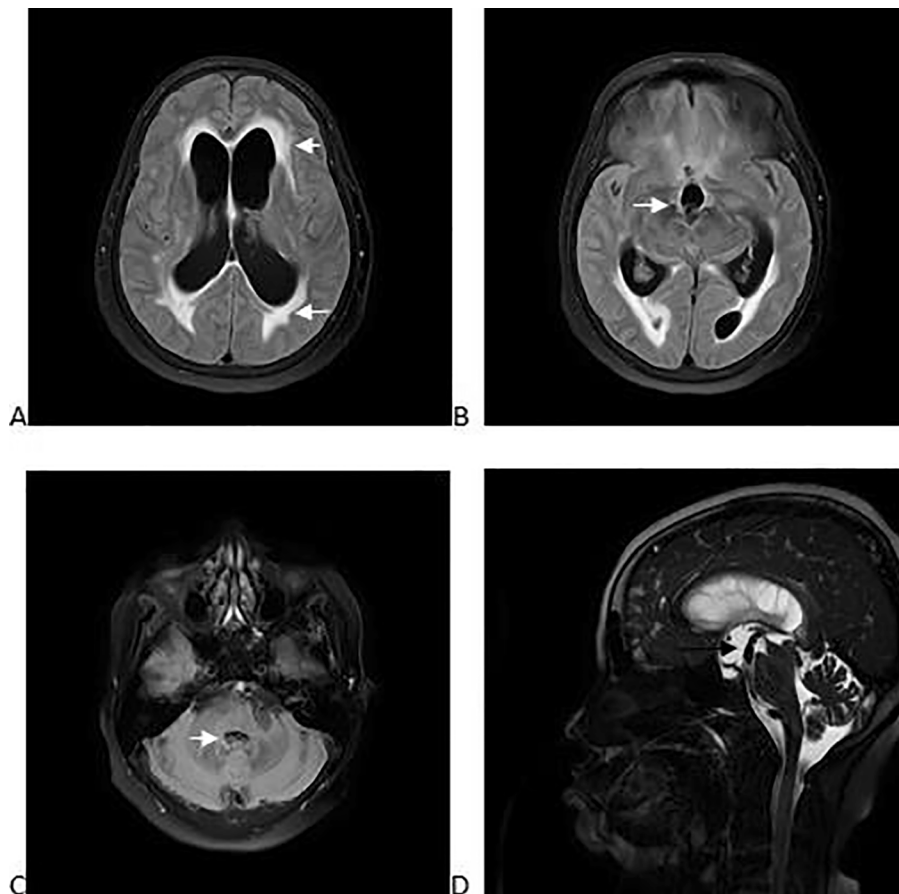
Magnetic resonance T2 FLAIR axial images showing triventriculomegaly (Panel A, B and C). Panel A showing dilated lateral ventricles with periventricular seepage and panel B showing dilated 3rd ventricle (white arrow) with normal sized 4th ventricle (panel C). MRI T2 weighted ssagittal image showing dolichoectatic basilar artery (black arrow) compressing floor of 3rd ventricle with decreased CSF flow through the cerebral aqueduct (panel D).
